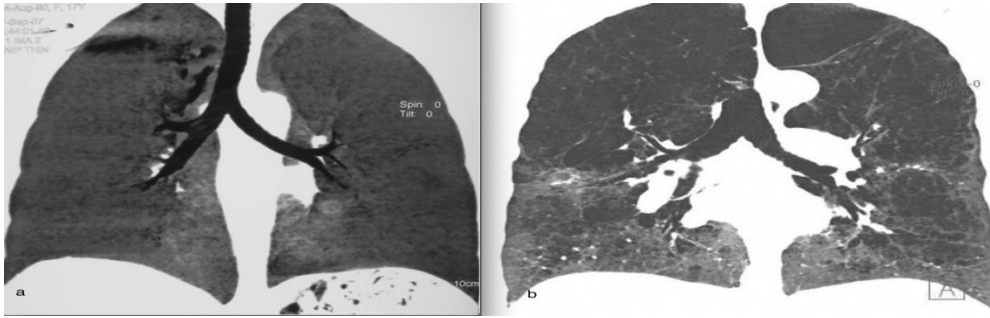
a. Multi-detector CT. Normal appearance of airways and lungs on MinIP. b Bullae and bilateral emphysema on minIP
